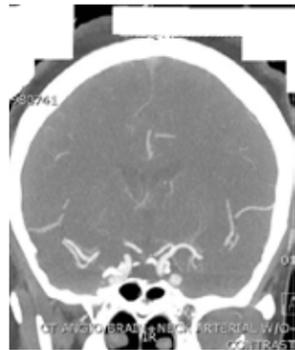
CTA showing left M2 clot (black arrow)
